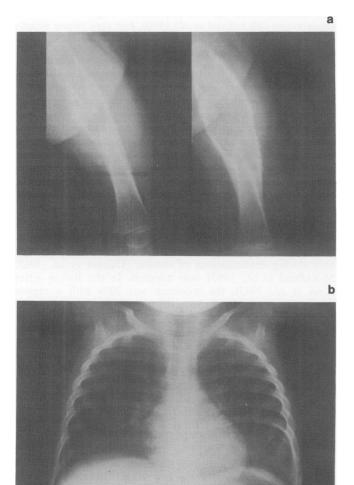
X-ray appearance of an LCH lesion in the femur in a baby who presented with a painful swollen thigh (a) aged 6 months and (b) aged 7 months. The extensive periosteal reaction mimics malignancy, especially Ewings sarcoma/PNET. Chest X-ray 2 years later (c) shows an osteolytic lesion in the L 9th rib.
